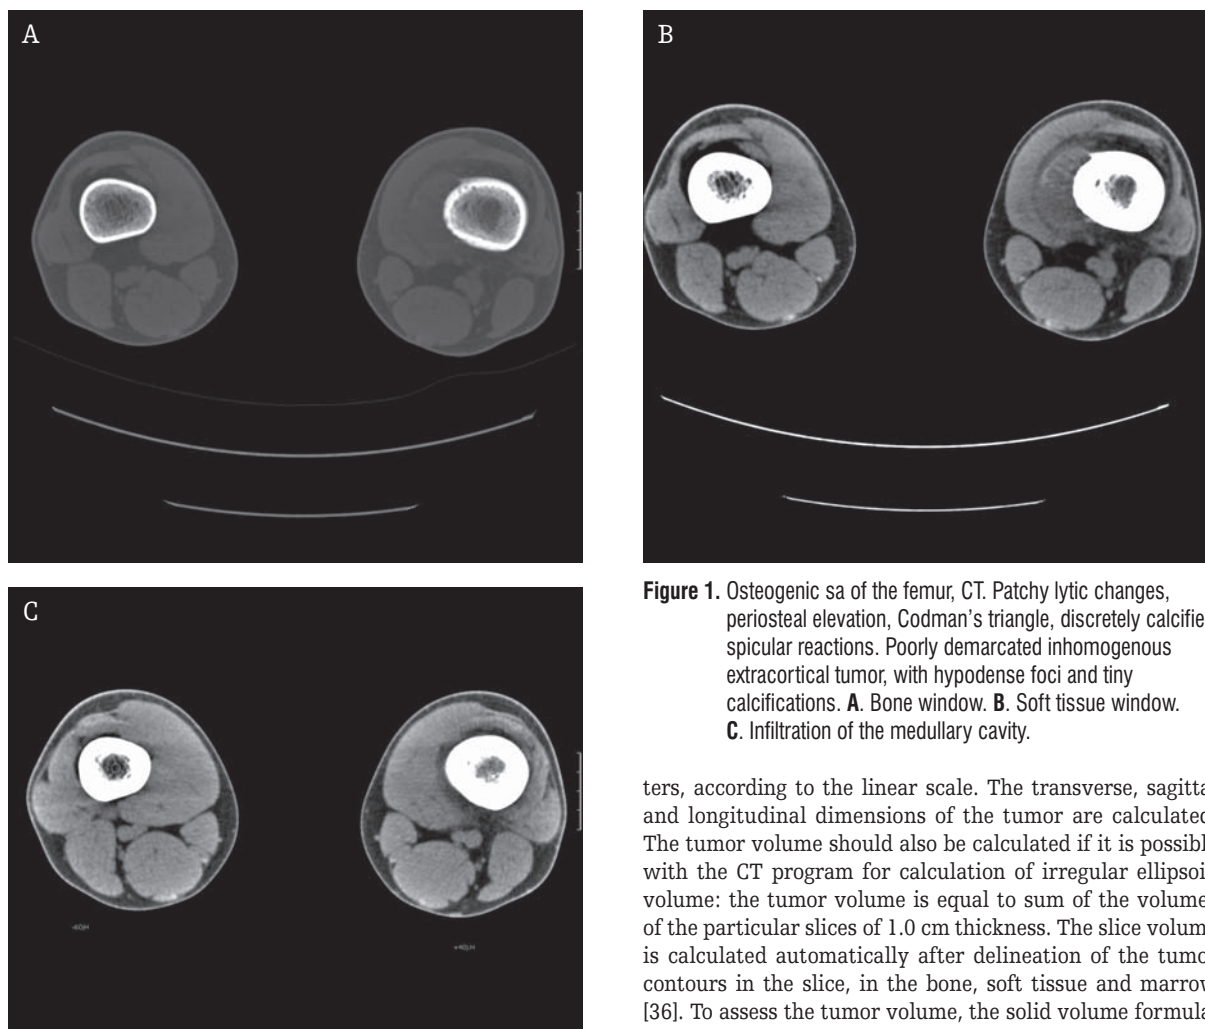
Osteogenic sa of the femur, CT. Patchy lytic changes, periosteal elevation, Codman's triangle, discretely calcified spicular reactions. Poorly demarcated inhomogenous extracortical tumor, with hypodense foci and tiny calcifications. A. Bone window. B. Soft tissue window. C. Infiltration of the medullary cavity.
